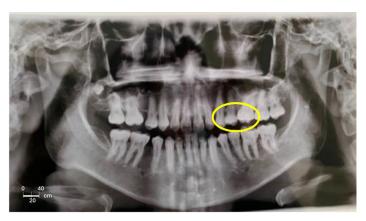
Examination of panoramic radiograph
